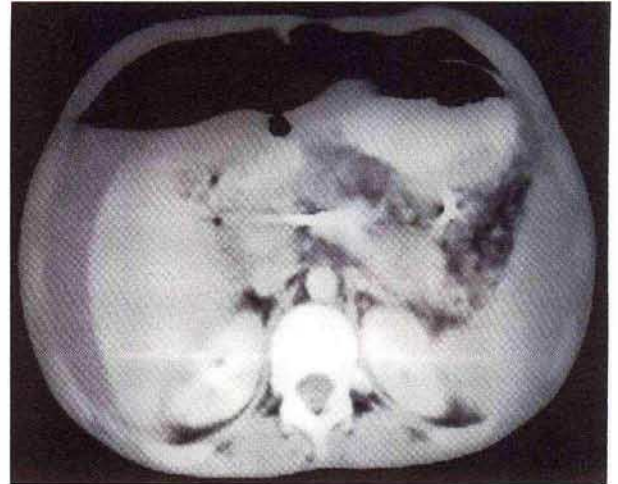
CT after the second ERCP, showing the transpapillary and cystogastrostomy stents and the pneumoperitoneum. The pseudocysts have been almost completely drained.
